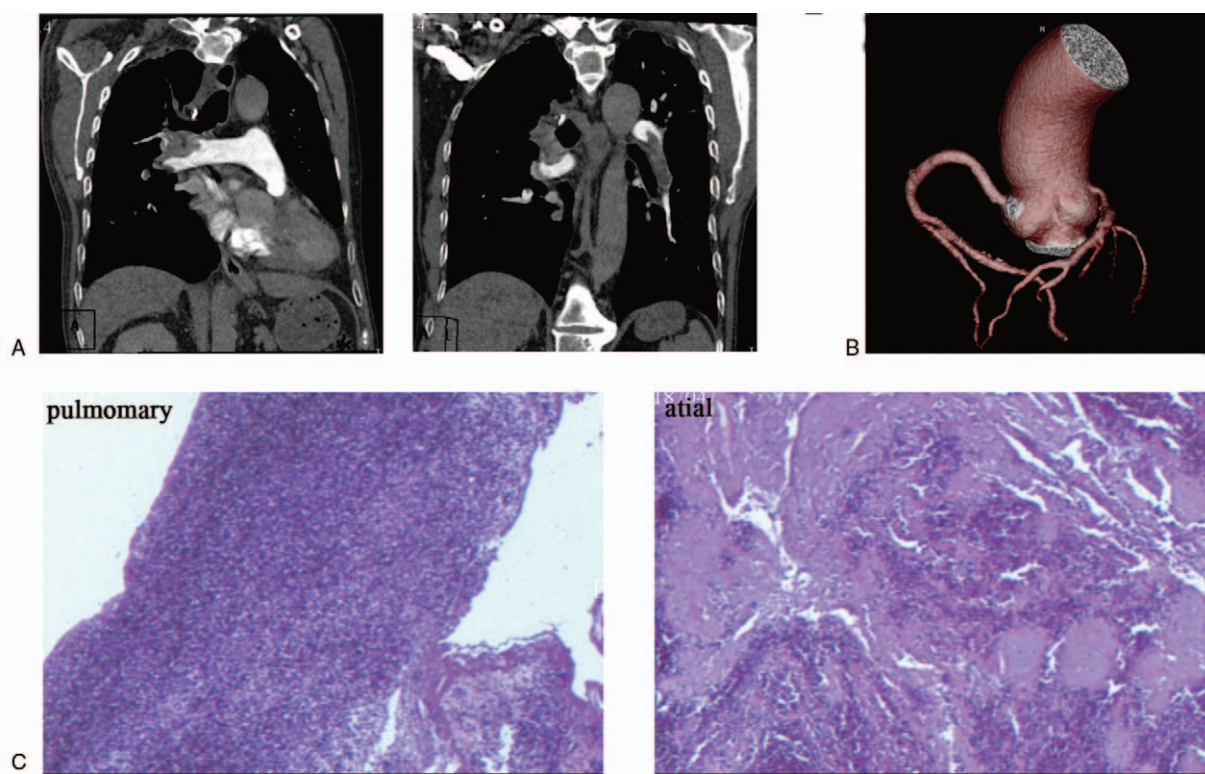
A, Large embolisms in bilateral pulmonary trunks in computed tomographic pulmonary angiography. B, No obvious stenosis in coronary computed tomographic angiography. C, The block masses in pulmonary artery and right atrium were both mixed thrombus.
